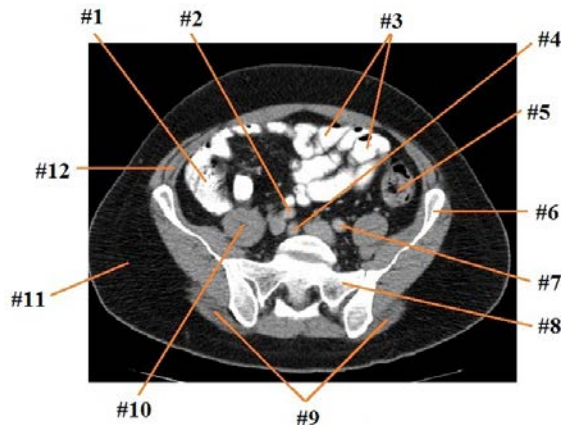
CT axial cross-sectional image of the pelvic region.
